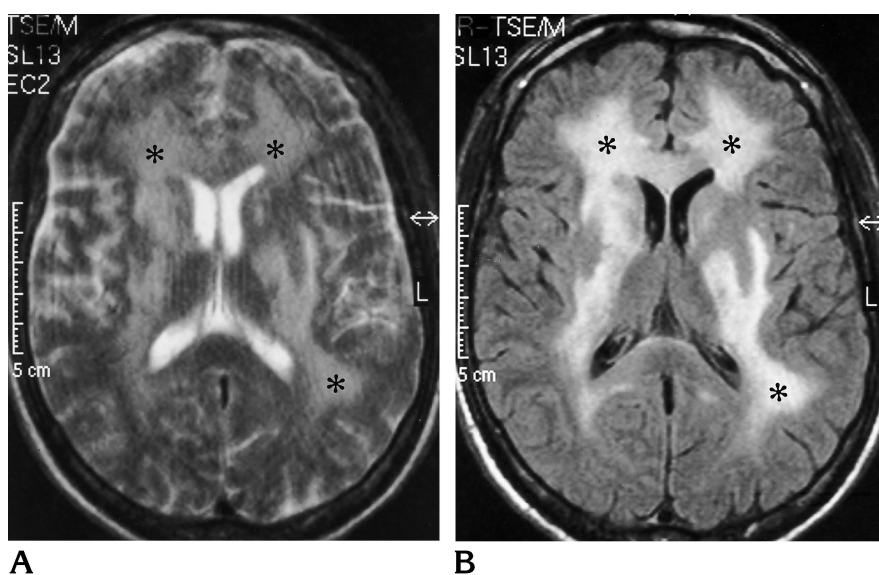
Autopsy-proved HIV encephalitis in a 35-year-old patient with AIDS. Diffuse white matter changes (*asterisks*) can be seen on both T2-weighted fast spin-echo (3452/120/4) (A) and FLAIR fast spin-echo (7000/150/4; inversion time, 2100) (B) MR sequences. The conspicuity is, however, slightly better in B.
